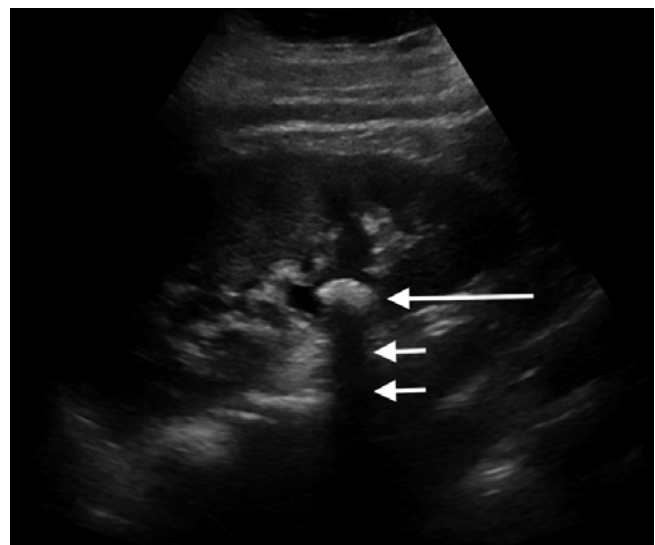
Renal calculus. Sagittal sonographic image of the right kidney demonstrates a calcified renal stone (*large white arrow*) with the classic appearance of an echogenic lesion causing posterior acoustic shadowing (*small white arrows*)
